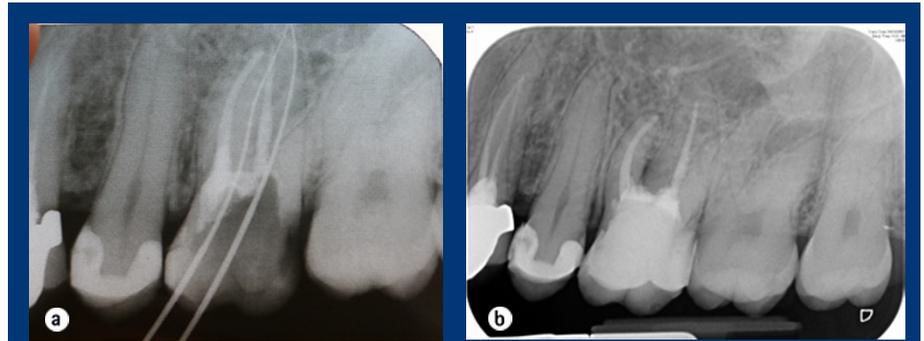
a) In an attempt to locate the disto-buccal canal of the 26, there were multiple perforations of the pulp chamber floor. b) Upon re-entry the disto-buccal canal could not be located but the perforation was repaired with MTA. There was radiographic evidence of furcational bone loss. The tooth remained symptomatic and the tooth was removed
